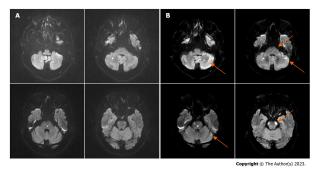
The brain diffusion-weighted magnetic resonance imaging at different time intervals. A: Diffusion-weighted magnetic resonance imaging
